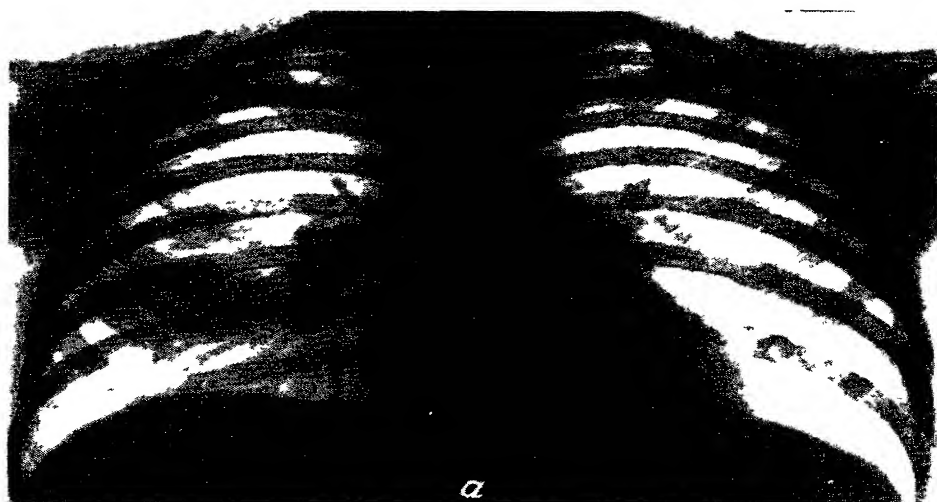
X-rays of patient FK
